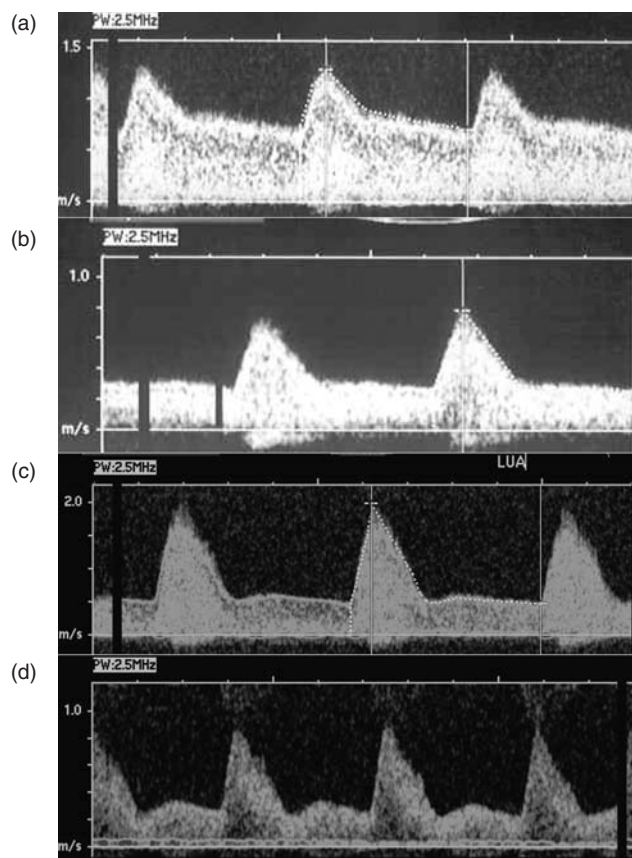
Flow velocity waveforms obtained from the uterine artery beyond 24 weeks gestation. In the first patient (a) high volume diastolic flow is established indicating successful trophoblast invasion. Elevated placental vascular resistance is associated with a decline in diastolic velocities and a subsequent rise in the Doppler index (b). Persistence of an early diastolic notch in the uterine artery flow velocity waveform is evidence of increased spiral artery blood flow resistance. Frequently, 'notching' is more subtle beyond 32 weeks (c) than in the late second or early third trimesters (d).
